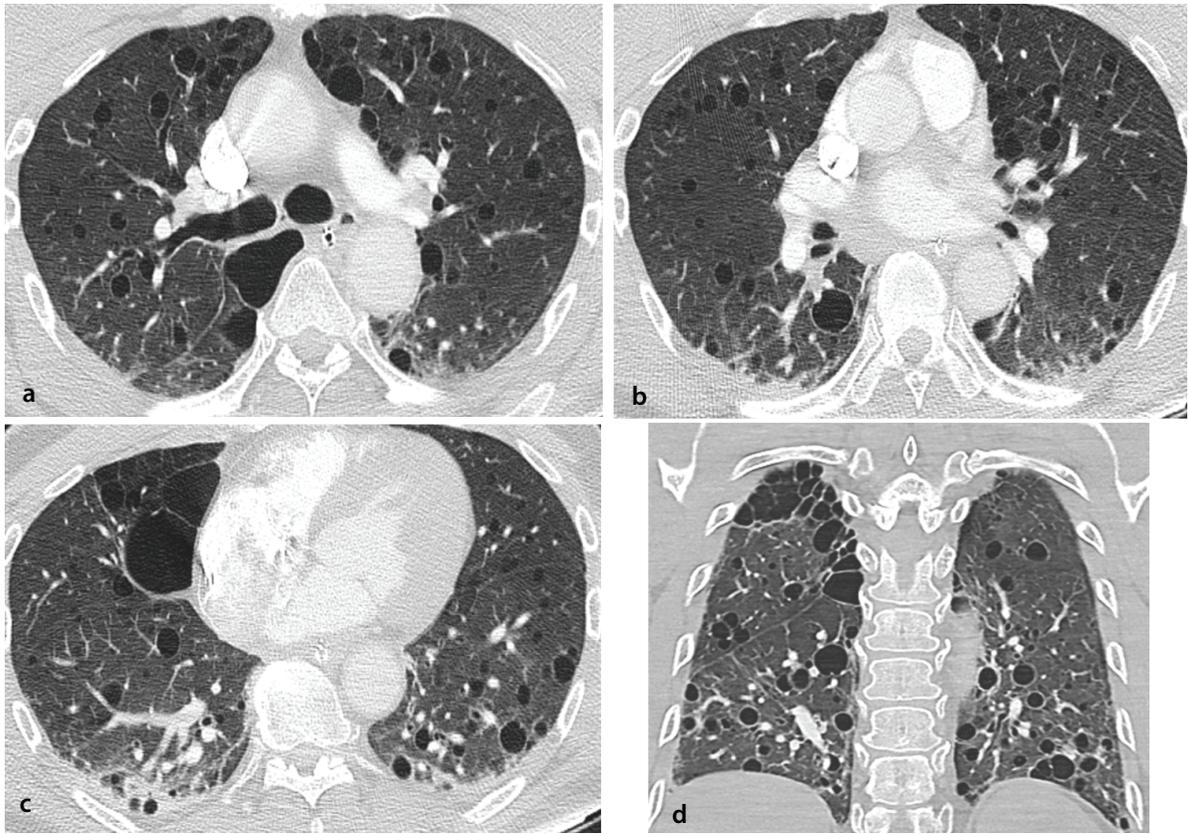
Lymphoid interstitial pneumonia (LIP) pattern on chest computed tomography (CT) in a patient with underlying Sjögren’s disease. Axial (a–c) and coronal (d) CT images show numerous thin-walled cysts of variable size, lower-lobe–predominant ground-glass opacities, and interlobular septal thickening, characteristic of LIP.
